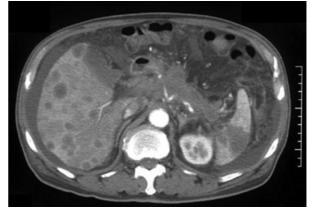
CT scan showing the pancreatic cancer invading the celiac trunk and the splenic artery, wedge-shaped splenic infarction and multiple hepatic metastases.
